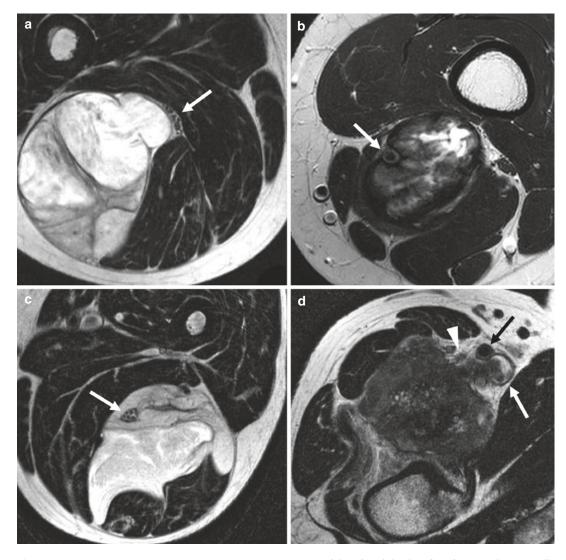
(a–d) Neurovascular encasement. (a) Axial T2-weighted TSE image shows myxoid liposarcoma abutting the sciatic nerve (*arrow*). The tumor contacts less than 180° of the neural circumference. Intraoperatively, the nerve could be dissected from the tumor. (b) Axial T2-weighted TSE image demonstrates fibromyxoid sarcoma contacting more than 180° of the circumference of the femoral artery (*arrow*). The arterial segment had to be resected en bloc with the tumor and be replaced by a graft.
